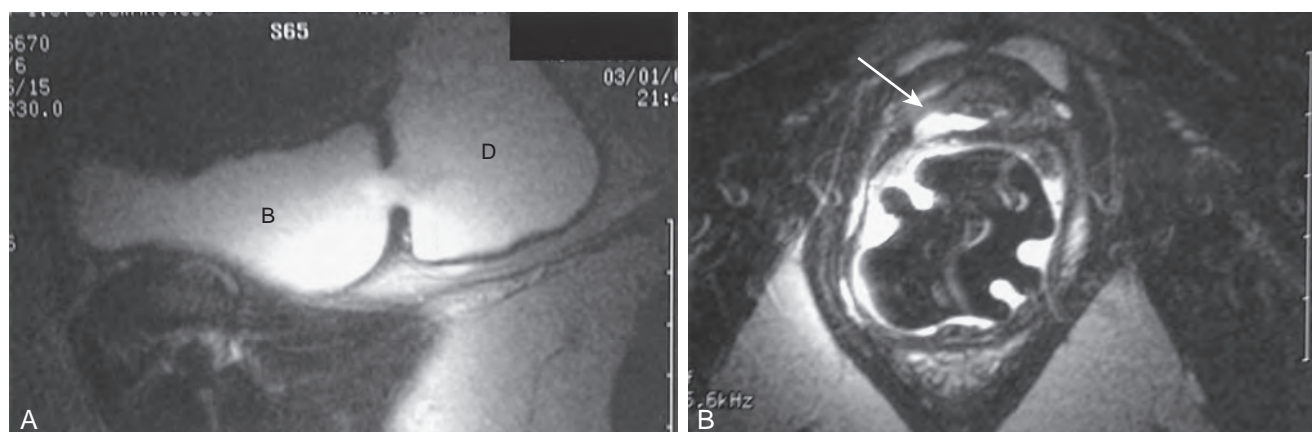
Bladder and urethral diverticula in a female. A, Magnetic resonance imaging (MRI) of a bladder (B) diverticulum (D). B, Endoluminal MRI demonstrating urethral diverticulum (arrow points to urethral diverticulum).
